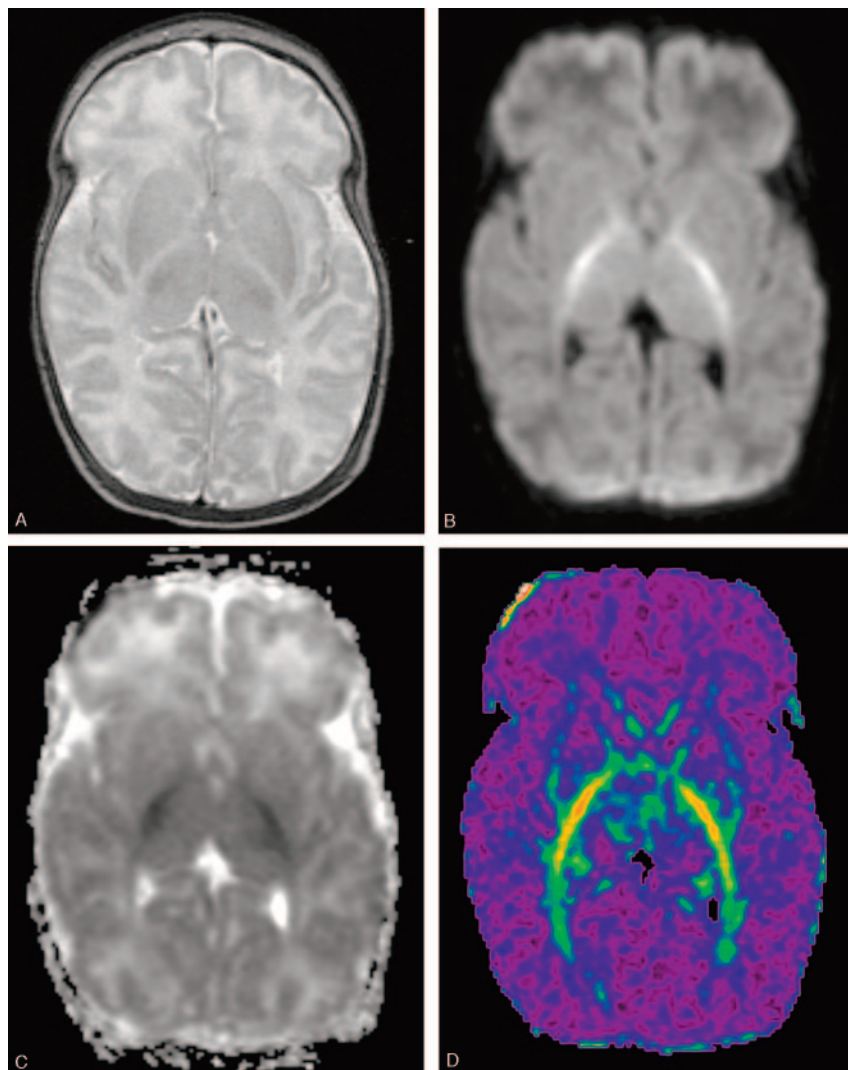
MR images at the age of 3 weeks.
